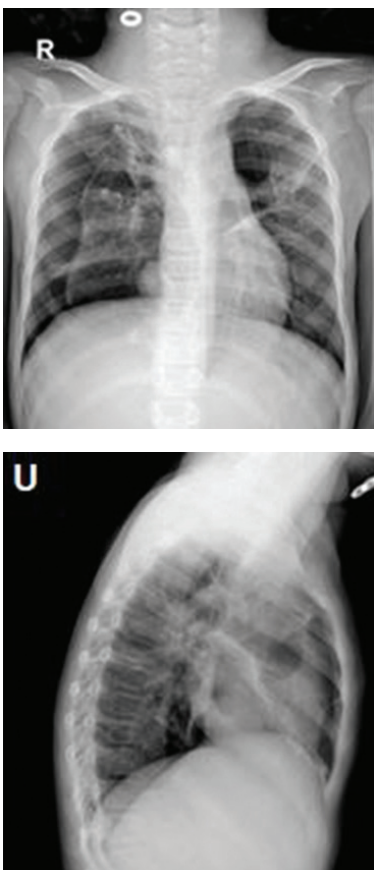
Chest radiograph showed pneumothorax on the right hemithorax, ovoid density on left upper lobe possibly bullous changes, and possible segmental atelectasis on the left hilum.
